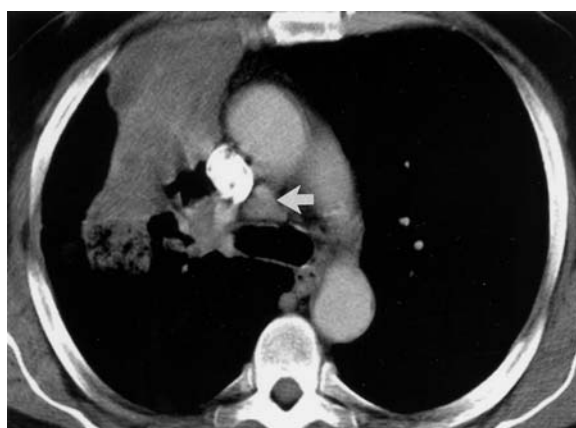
False-positive lymph node. Axial CT image shows a central neoplasm obstructing the right upper lobe bronchus, with associated post-obstructive atelectasis and pneumonitis. Enlarged precarinal lymph node (arrow) proved to be hyperplastic at biopsy, with no evidence of neoplasm
